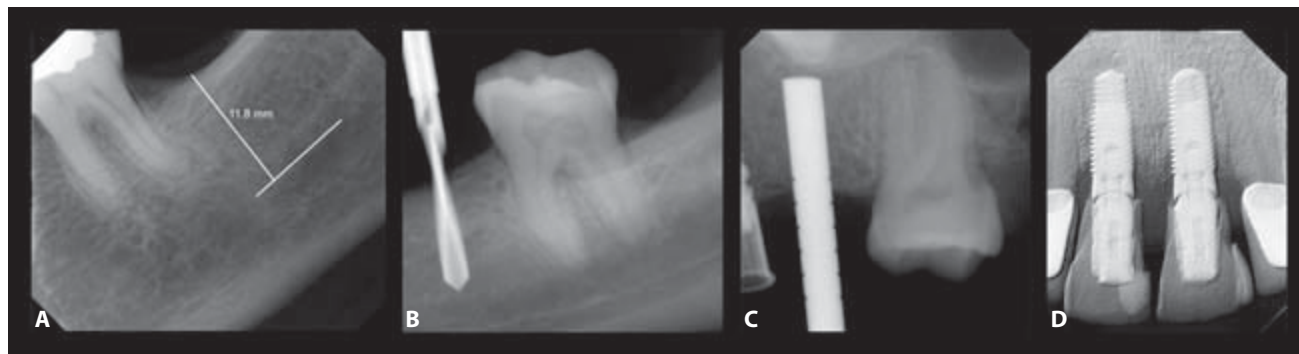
A. Digital periapical radiographic views showing direct measurement of the bone height. B. Digital periapical radiographic views showing the detection of the drilling depth. C. Digital periapical radiographic views showing the relationship to the anatomical vital structure. D. A 3D view of the periapical digital radiograph.
